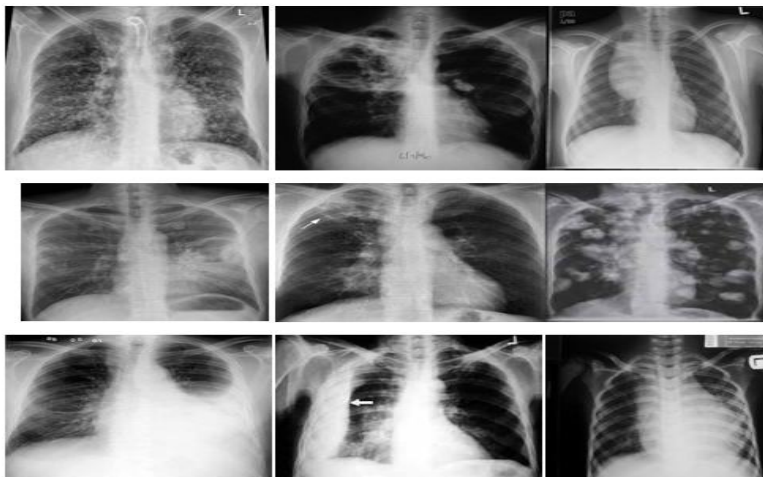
Chest X-ray panel for Pulmonary TB. Note that TB may present not only with cavities but with a wide variety of CXR abnormalities. Lateral CXR can be very helpful to diagnose lymphadenopathies in the Thorax that can key to diagnose TB in children (see chapter 6)
